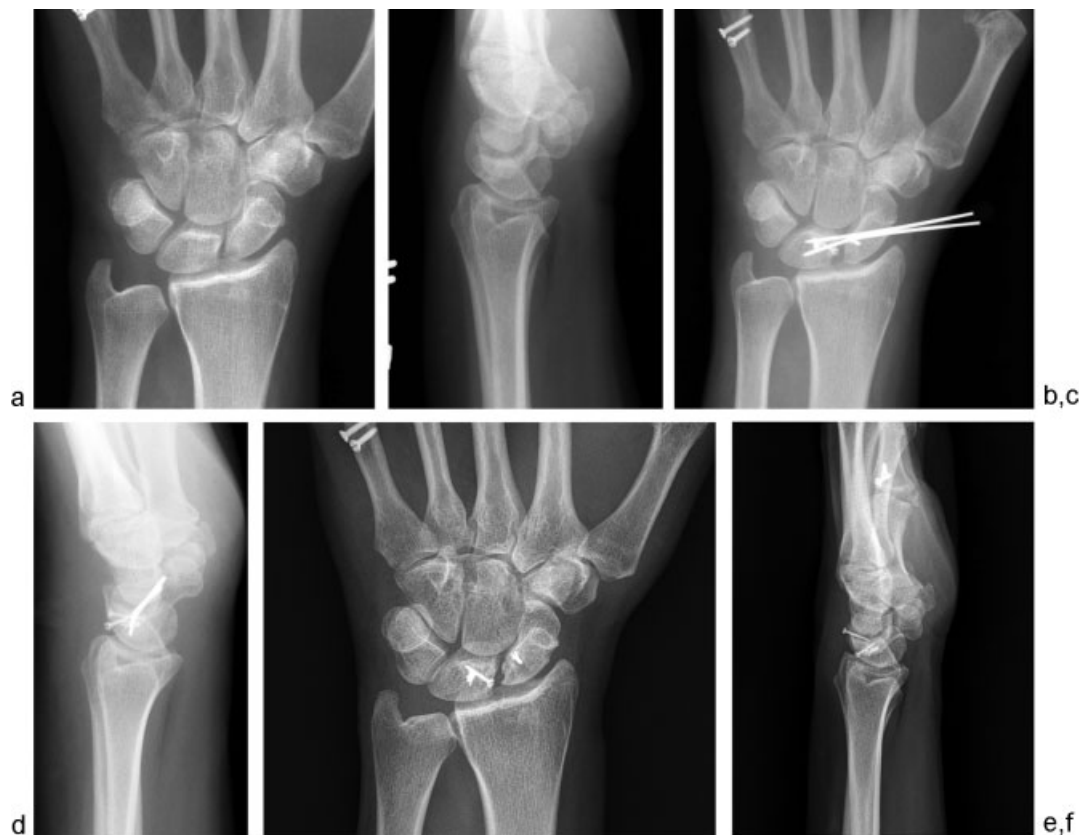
(a,b) AP and lateral radiographs of wrist 12, demonstrating SL instability before capitohamate BLB procedure. (c,d) Immediate postoperative AP and lateral radiographs after capitohamate BLB procedure in wrist 12, demonstrating reduction of the SL articulation. (e,f) AP and lateral radiographs at final follow-up (142 months postoperatively) in wrist 12, demonstrating maintenance of the SL relationship and preservation of joint space.
